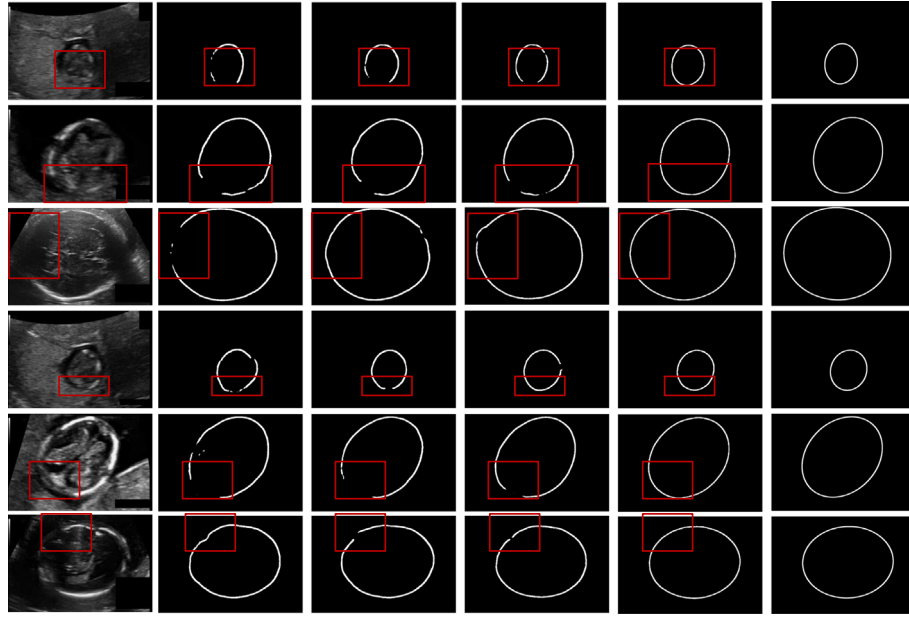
Qualitative evaluation of boundary detection ablation studies on the HC-18 training set with 10-fold cross-validation. The first and the fourth row show examples with poor fetal head boundary contrast to the background. The images in the second and the fifth row are examples of fetal head boundary-blurring regions. The third and the sixth row presents examples with boundary missing regions. Each column shows the original ultrasound images (first column), the corresponding ellipse annotations (sixth column), the ellipse detection results obtained by Model 1 (second column), Model 2 (third column), Model 3 (fourth column), Model 4 (fifth column), respectively.
